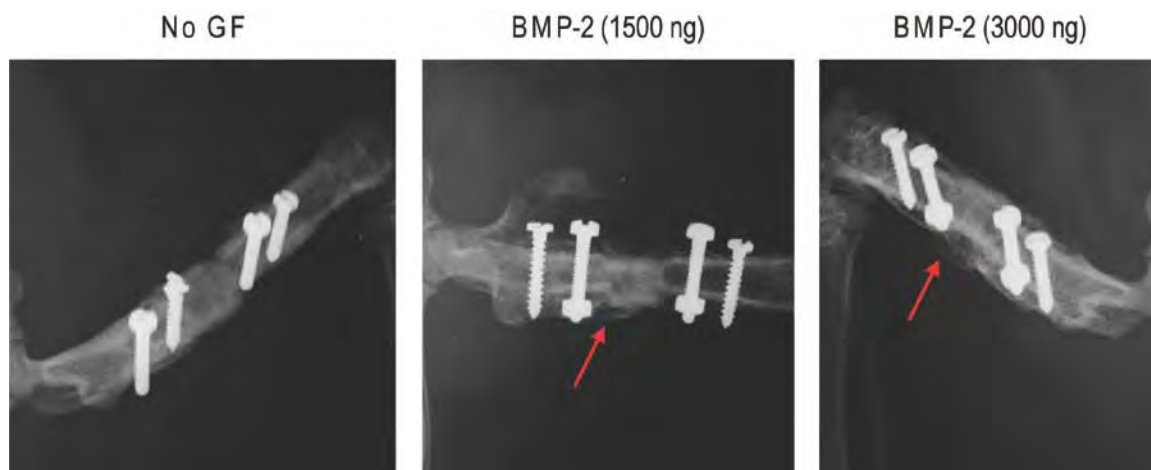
At 8 weeks post-operation, x-ray radiography revealed varying levels of bony bridging (red arrows) over the femoral defects filled with devitalized allografts wrapped with synthetic periosteum pre-loaded with 0 (no growth factor), 1500-ng, or 3000-ng rhBMP-2.
